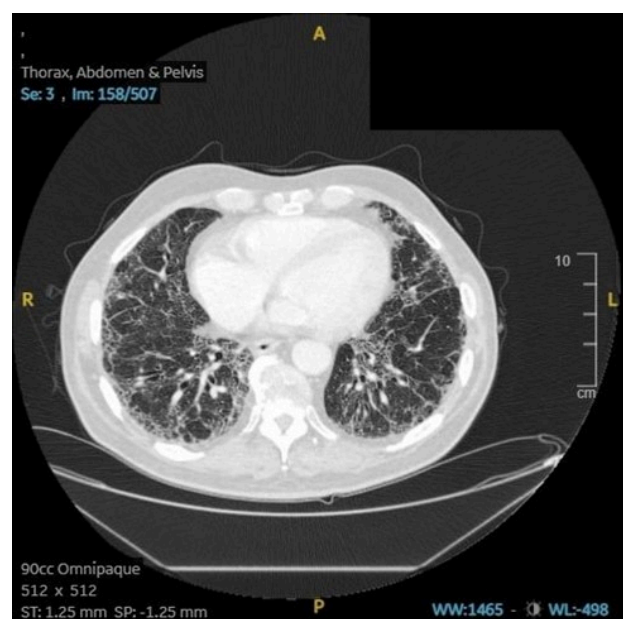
Repeat CT Thorax 3 months after treatment
